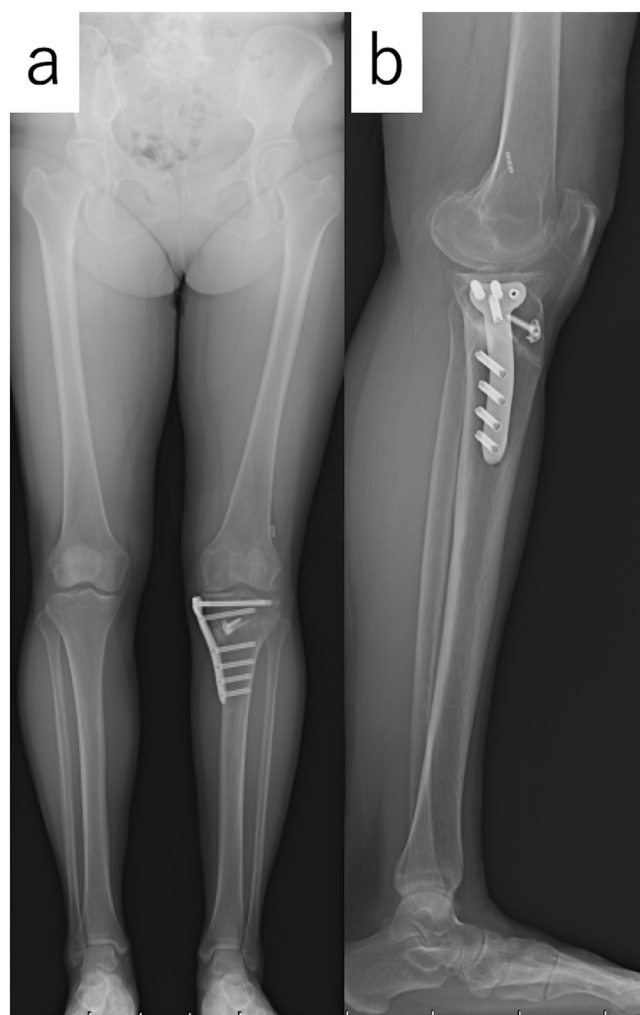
Whole leg radiographs a year after anterior cruciate ligament reconstruction with anterior closing wedge osteotomy.
